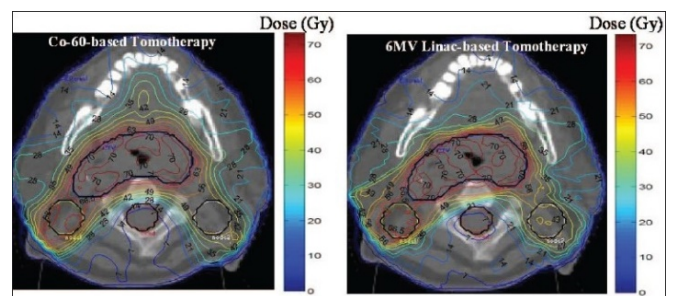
Tomotherapy distributions using cobalt-60 or 6 MV x-rays. With permission from [79].
